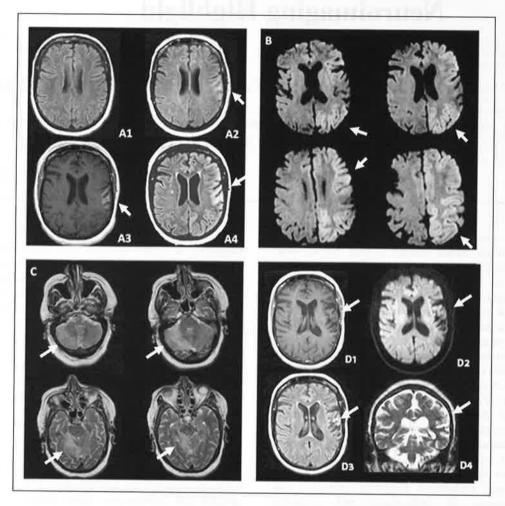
Serial MRI findings in a 52 year-old woman with adult-onset Rasmussen's encephalitis. (A1) Axial FLAIR image at one year disclosing no obvious abnormalities; (A2) Axial FLAIR image at same level at two years showing perisylvian hyperintense signal; (A3/A4) MRI findings at three years during acute complex partial status epilepticus; (A3) Axial contrast-enhanced T1-weighted image revealing mild subcortical frontal operculum enhancement; (A4) Axial FLAIR image showing mild progression of frontal operculum hypersignal. (B) DWI axial images demonstrating restricted diffusion throughout the left cerebral cortex. (C) Axial T2-weighted images through cerebellum showing signal abnormalities in the right cerebellum hemisphere consistent with crossed cerebellar diaschisis. (D) Control images at three months after status control showing (D1) resolution of opercular enhancement on axial T1-weighted image post-gadolinium; (D2) resolution of left hemispheric restricted diffusion on axial DWI axial image as well as crossed cerebellar diaschisis (not shown); (D3/D4) and mild left perisylvian atrophy axial FLAIR image and coronal T2 image.
